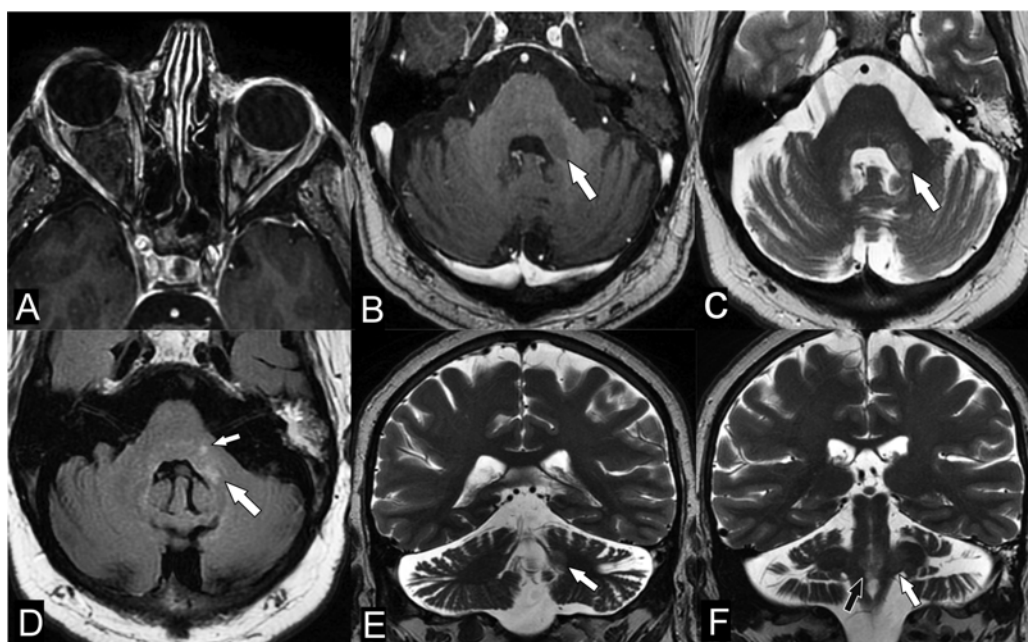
Post-contrast axial T1-weighted magnetic resonance imaging (MRI) after 12 years follow-up demonstrates residual, no enhancing (A) right orbital, retrobulbar, intraconal scar tissue with significantly less pronounced exophthalmos and the absence of left retrobulbar infiltration, as well as (B) a hypointense gliotic scar in the left middle cerebellar peduncle (white arrow). Axial T2-weighted (C), T2-weighted fluid attenuated inversion recovery (D) and coronal T2-weighted (E, F) MRI demonstrates a slightly hyperintense gliotic scar in the left middle cerebellar peduncle (white arrows) and in the pontine tegmentum (black arrow).
